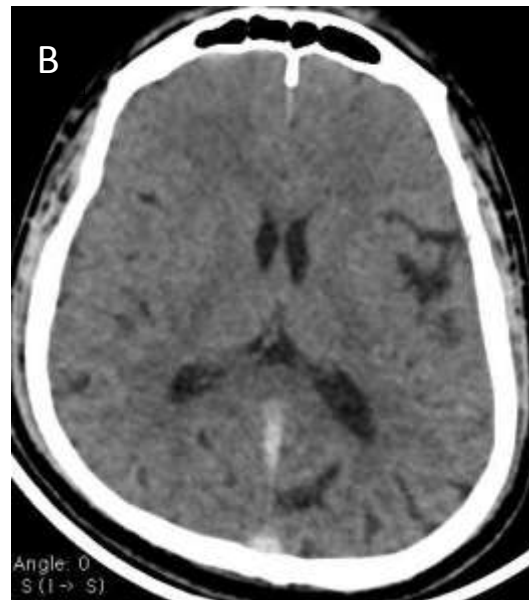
A and B: axial sections of CT brains showing normal SSS (A) and hyperattenuating SSS in CVT (B)
